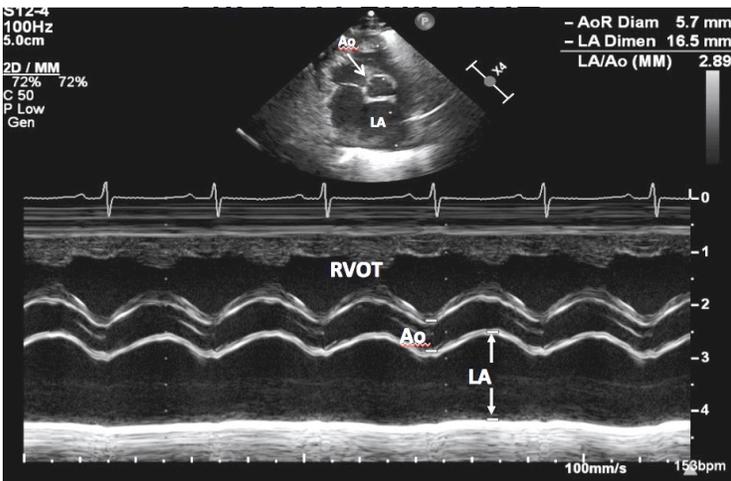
M-mode tracing in the parasternal short axis view demonstrating measurements of the aorta (Ao) and left atrium (LA) (arrows). Note that the LA/Ao ratio is increased (2.89:1). RVOT, right ventricular outflow tract.
